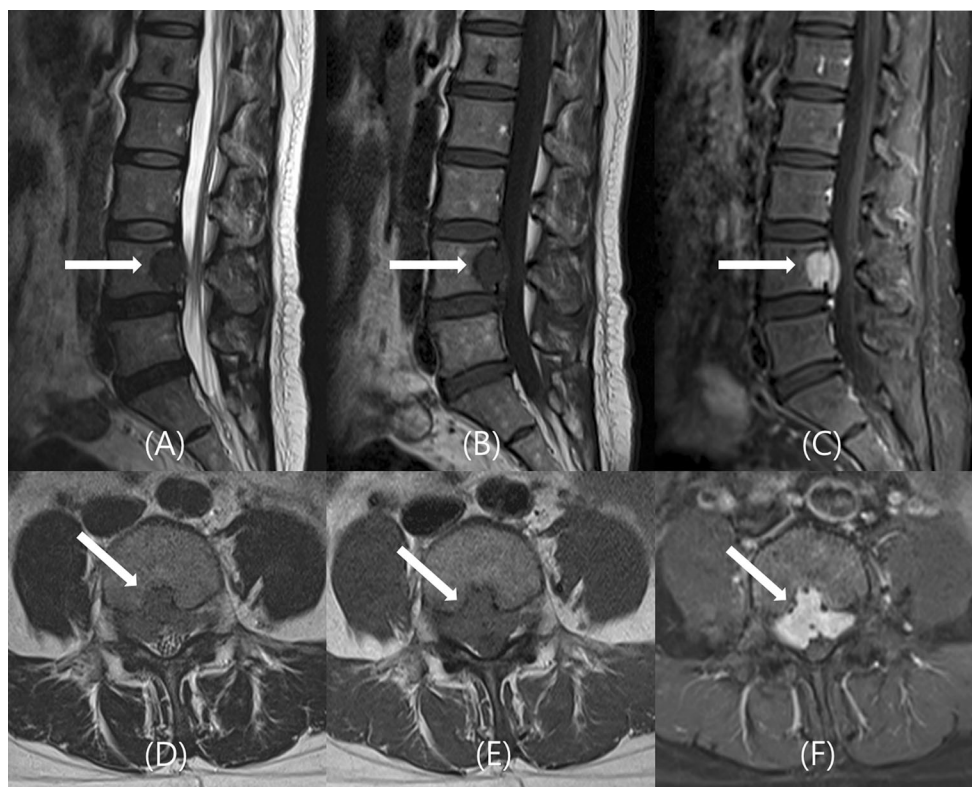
A well-defined mass lesion was noticed on MRI in the posterior compartment of the L4 vertebral body (arrows), with extension into the ventral epidural space. The mass showed hypointensity on both T2- (a, d) and T1- (b, e) weighted images. The lesion
